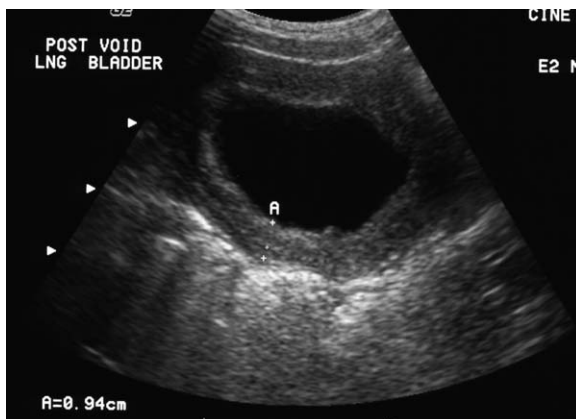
A renal/bladder ultrasound in an 8-year-old boy.
